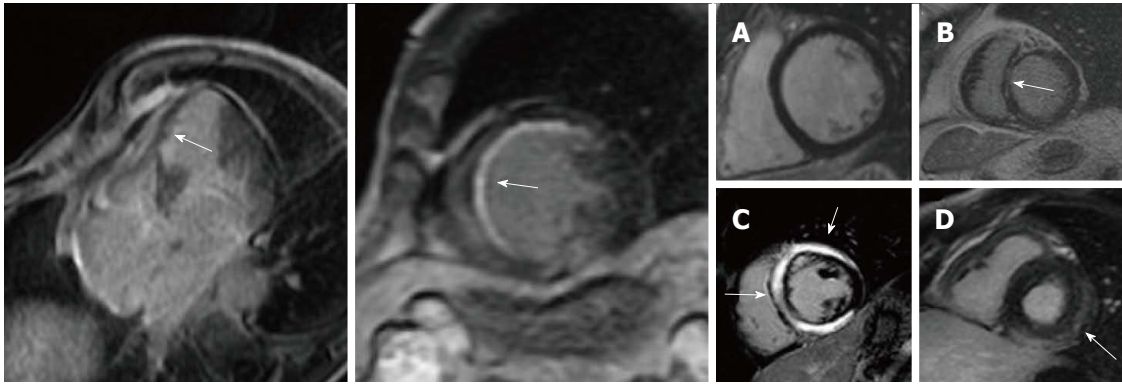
Late gadolinium-enhanced cardiac magnetic resonance images of ischemic (left panel) and non-ischemic (right panel) dilated cardiomyopathy. In ischemic cardiomyopathy LGE has a subendocardial or transmural distribution in myocardial segments following a coronary artery. In non-ischemic etiology, it shows a “midwall” pattern (panel B, C) or subepicardial distribution (panel D). LGE: Late gadolinium enhancement.
